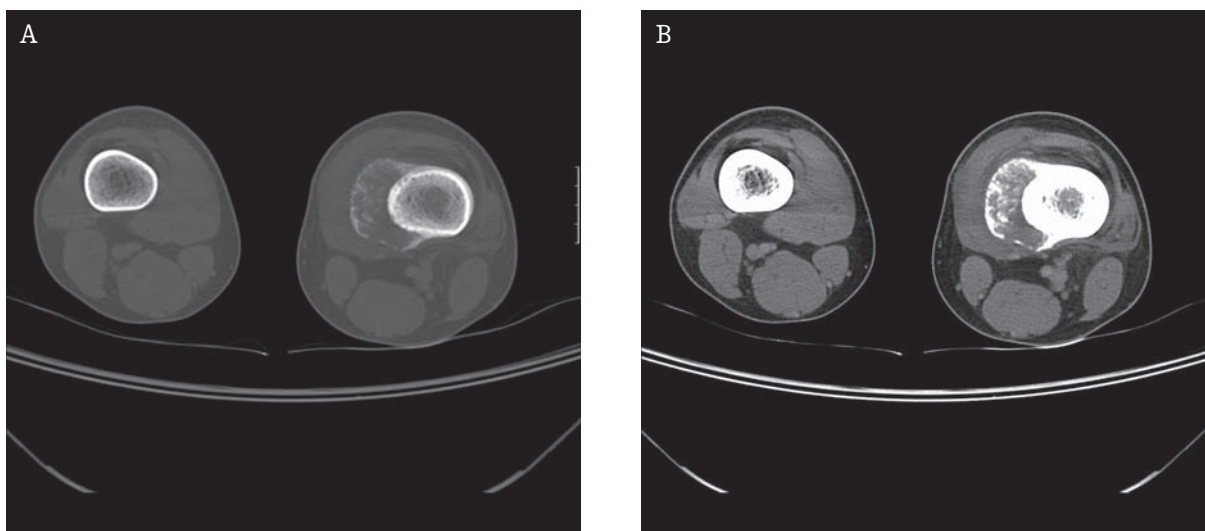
Osteogenic sa of the femur, preoperative CT (the same patient as in fig. 12). Sclerotic changes of cortical bone, calcification of periosteal reactions, calcifications in the extracortical tumor. Big regions of the tumor still uncalcified. A. Bone window. B. Soft tissue window.
